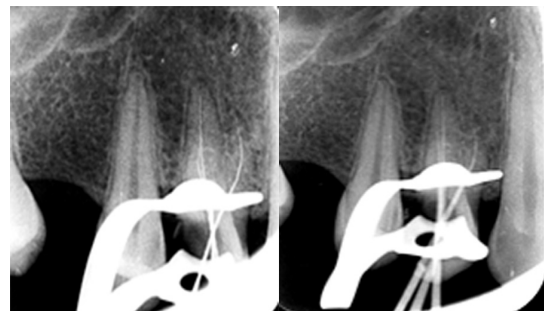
Radiographical confirmation of the three root canals and determination of the working lengths.
